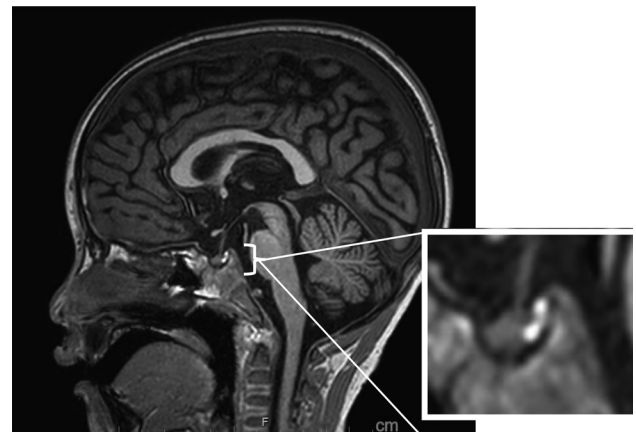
Magnetic resonance imaging scan of patient head on the 4th day of admission. Magnetic resonance imaging on T1 weighted scan of the head revealed no alterations related to the head injury. A high signal intensity was observed in the posterior pituitary gland.
